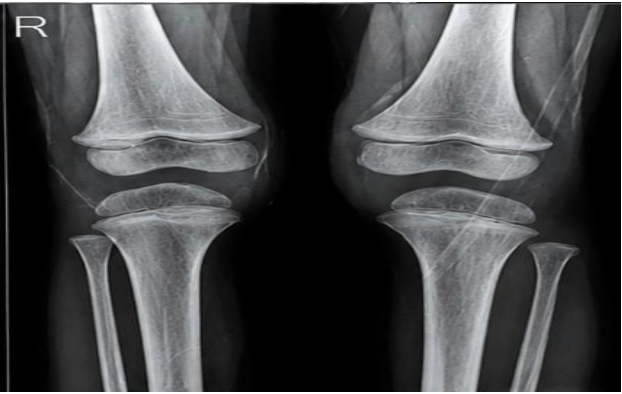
Case 3: X-ray of bilateral knee joints of twin 2 suggesting synovitis like changes.
